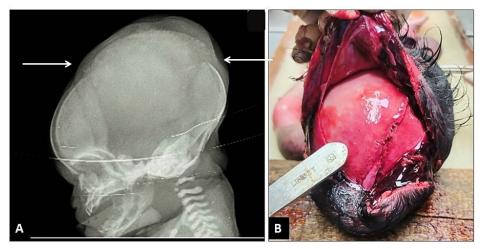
(A) Postmortem x-ray of skull showing overriding of cranial bones and edema of the scalp. (B) Gross image showing overriding of cranial bones and edema of the scalp
